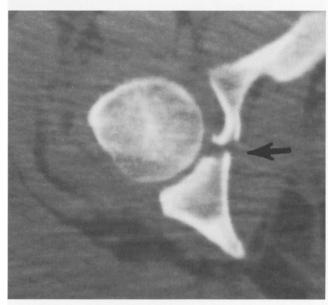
The CT at the inferior acetabulum confirms a quadrilateral plate fracture into the obturator ring.
